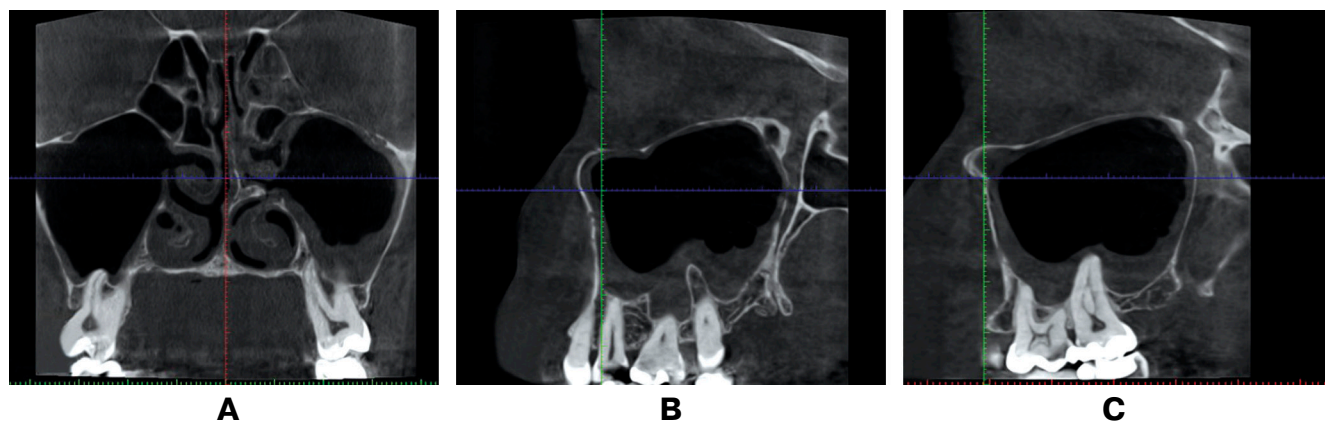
CBCT of Patient G. (41 years) in the coronal (A) and sagittal planes (B, C): apices of teeth 1.4–2.7 in close proximity to the maxillary sinus floor
